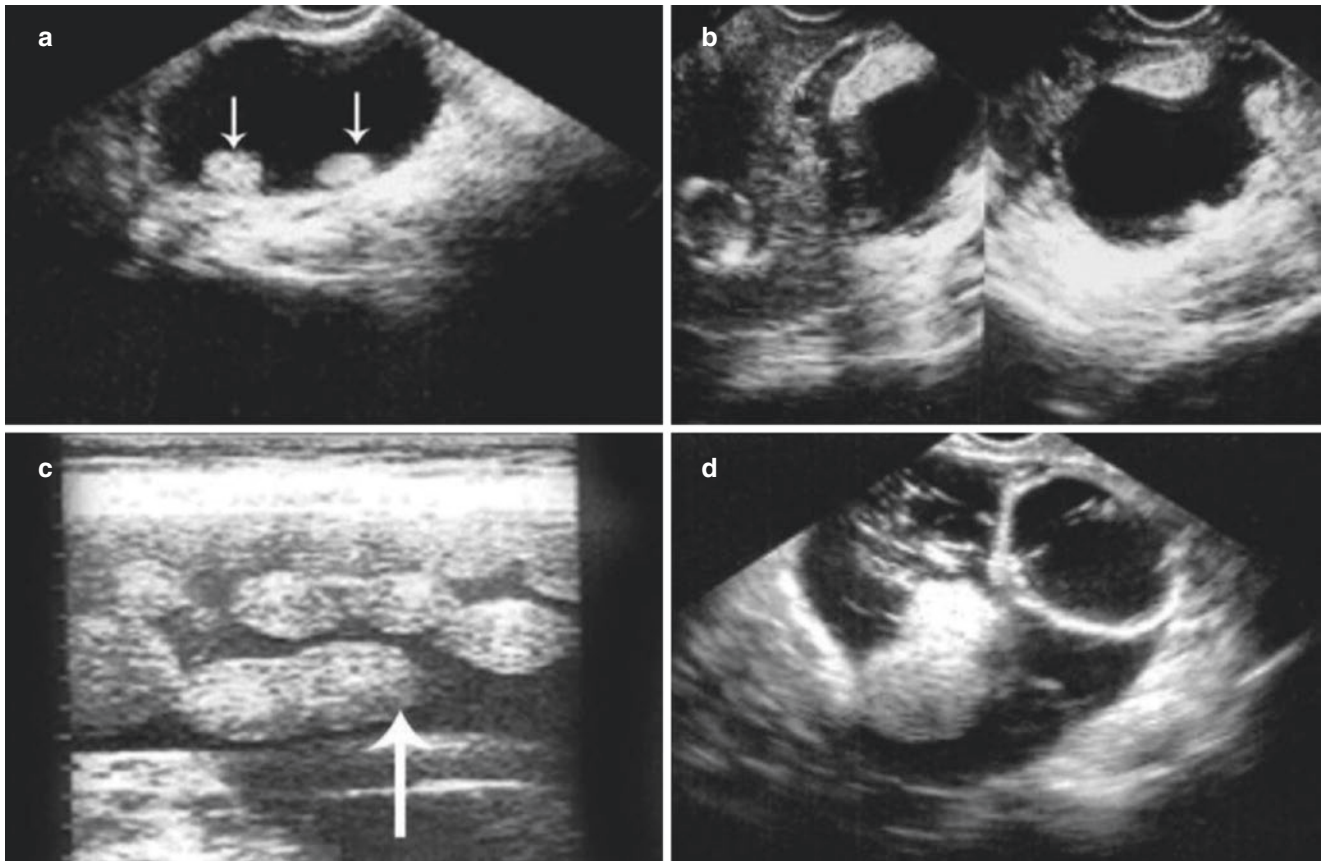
Ovarian teratoma (V). (a, b) The mass is mainly cystic, with solid nodule protruding into the cystic cavity on the inner wall of the cyst. (c) A 52-year-old patient represented abdominal enlargement for half a year. Sonogram shows a huge cystic mass with multiple mobile
